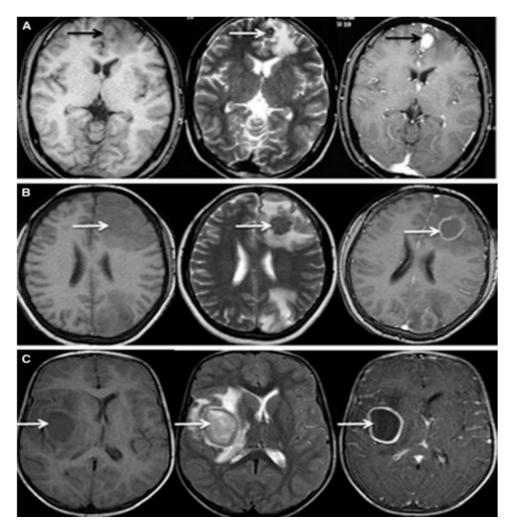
Magnetic resonance imaging appearance of tuberculoma based on different stage of maturation⁵²
